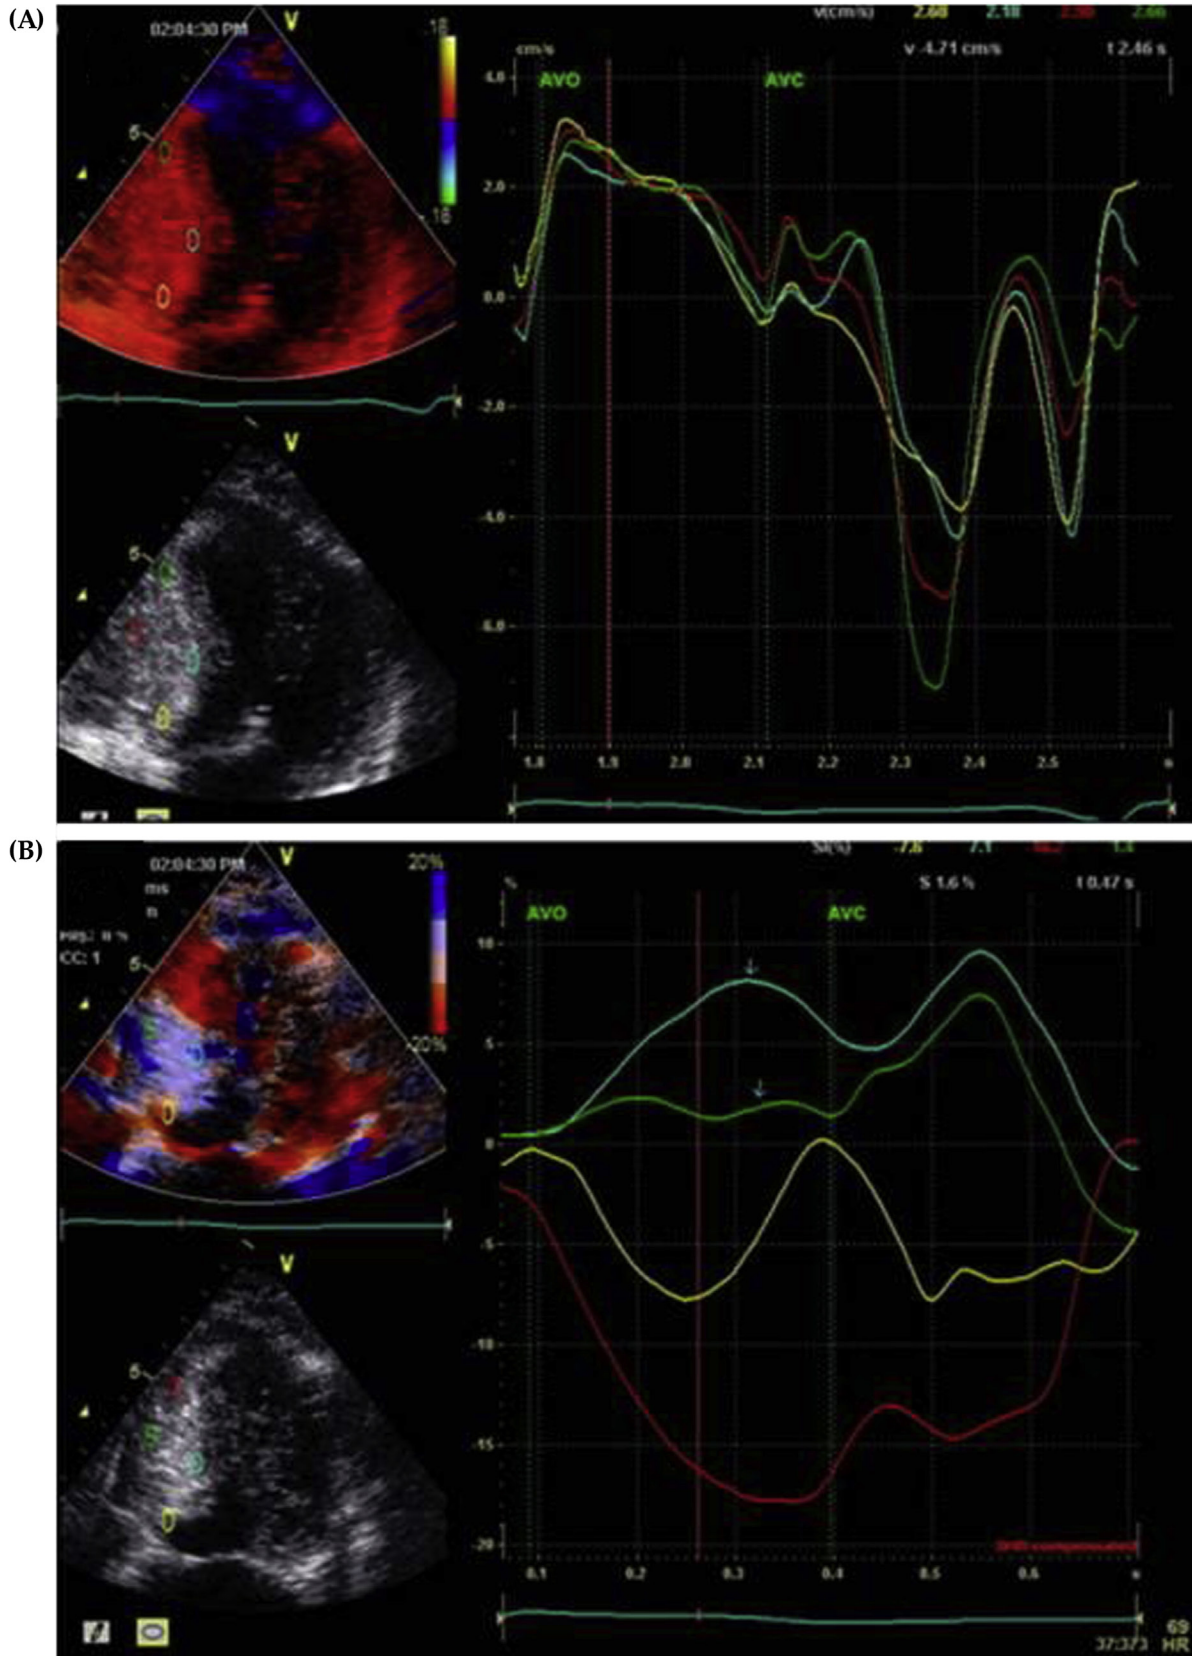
Assessment of left ventricular (LV) dysfunction by means of tissue Doppler (A) derived strain and 2D strain (B) imaging techniques from four representative regions of interest in a patient with Sjögren's syndrome. Note the significantly attenuated systolic and early diastolic velocities from these disparate regions in the septum (A). Note the positive longitudinal strain (systolic lengthening) or "paradoxical strain" (blue and green tracings) in two of the four depicted regions (basal septum) and attenuated longitudinal strain elsewhere (yellow tracing). Also note the striking heterogeneity of the strain tracings in contrast to tissue Doppler data. AVO, aortic valve opening; AVC, aortic valve closure. *Adapted from the personal collection of the authors.*
